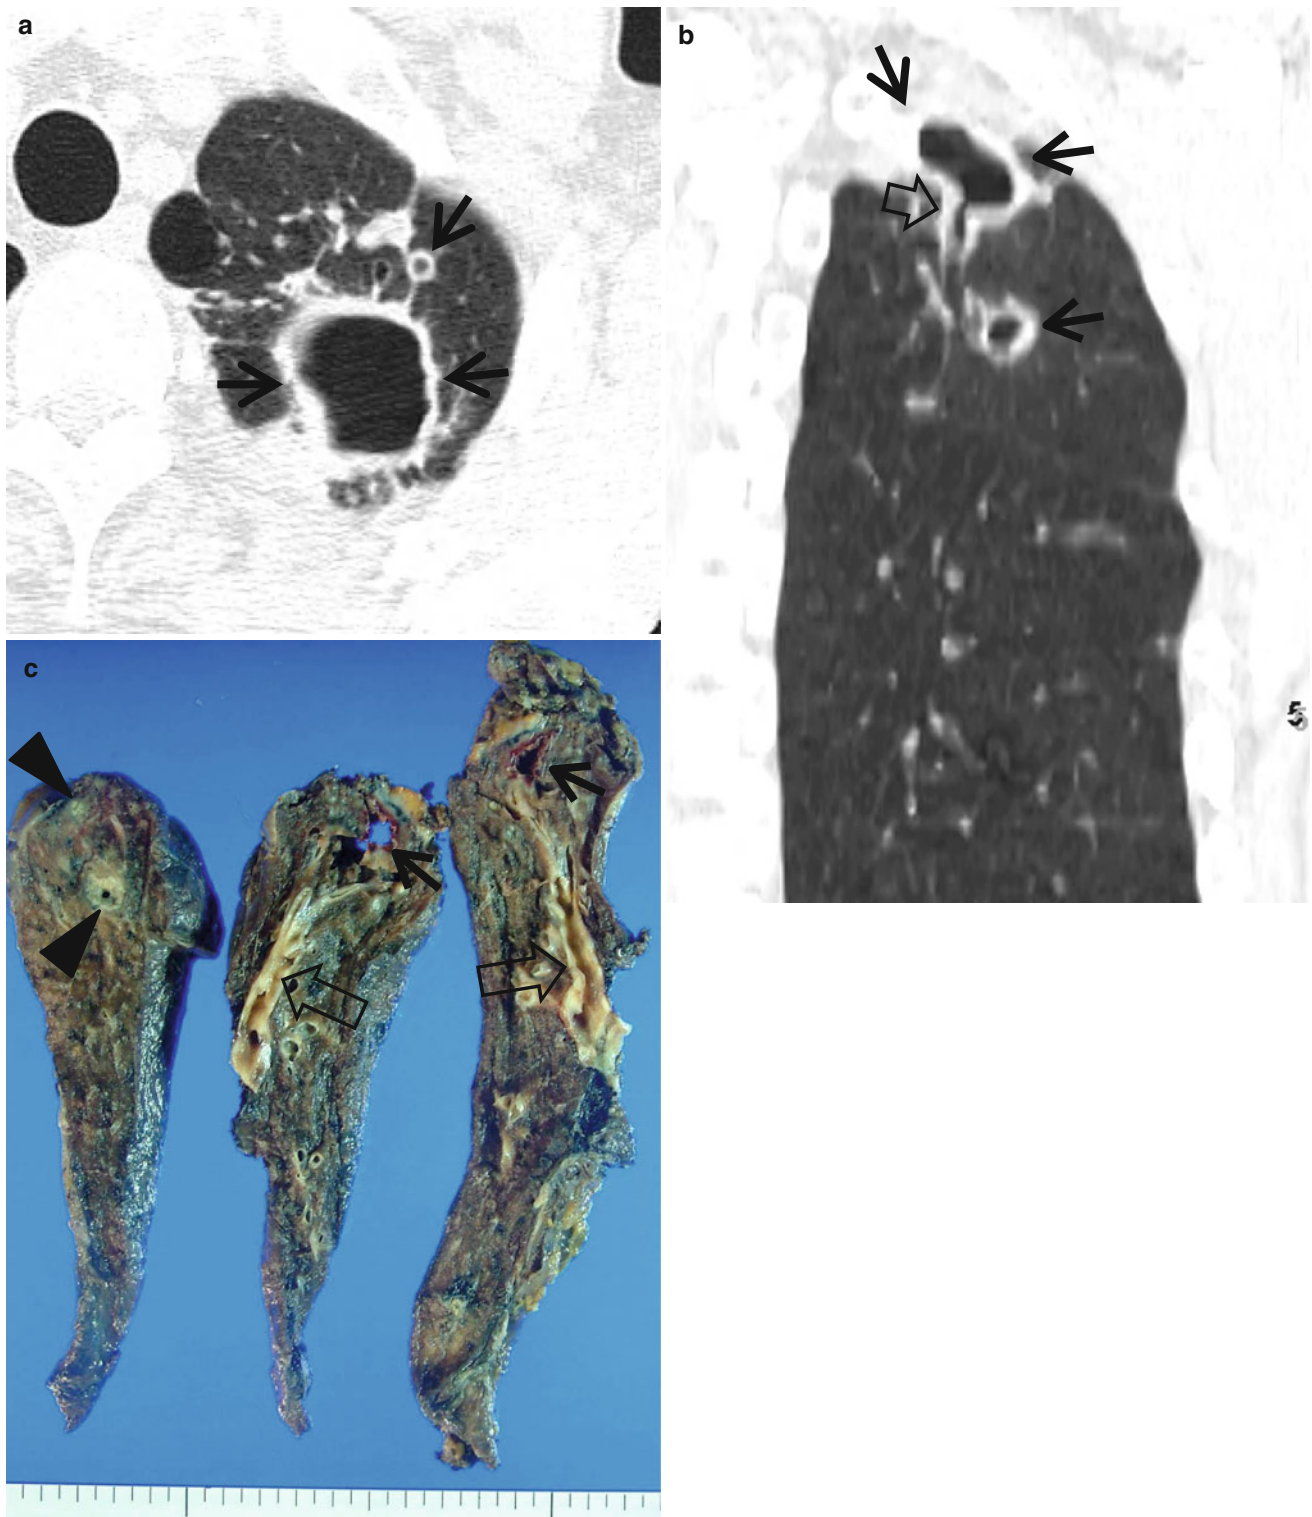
Nontuberculous mycobacterial pulmonary disease of upper lobe fibrocavitary form (*M. intracellulare*) in a 64-year-old man. (a) Lung window image of CT scan (2.5-mm section thickness) obtained at level of great vessels shows relatively even cavity wall thickness (arrows) in left apical area. Also note variable-sized nodules. (b) Coronal reformatted image (2.0-mm section thickness) demonstrates
